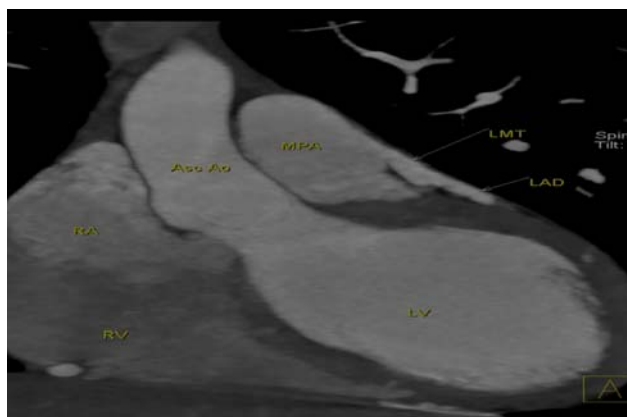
(a). Preoperative coronal section of CT scan showing the origin of LMCA from pulmonary artery.
